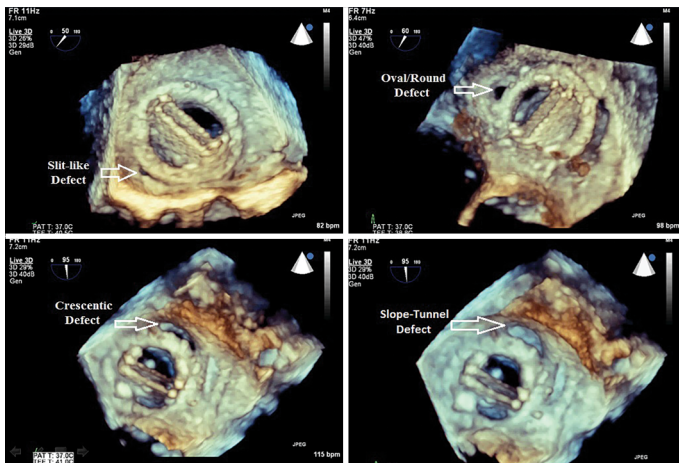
Multiple types of PVLs demonstrated by real-time three-dimensional transesophageal echocardiography
